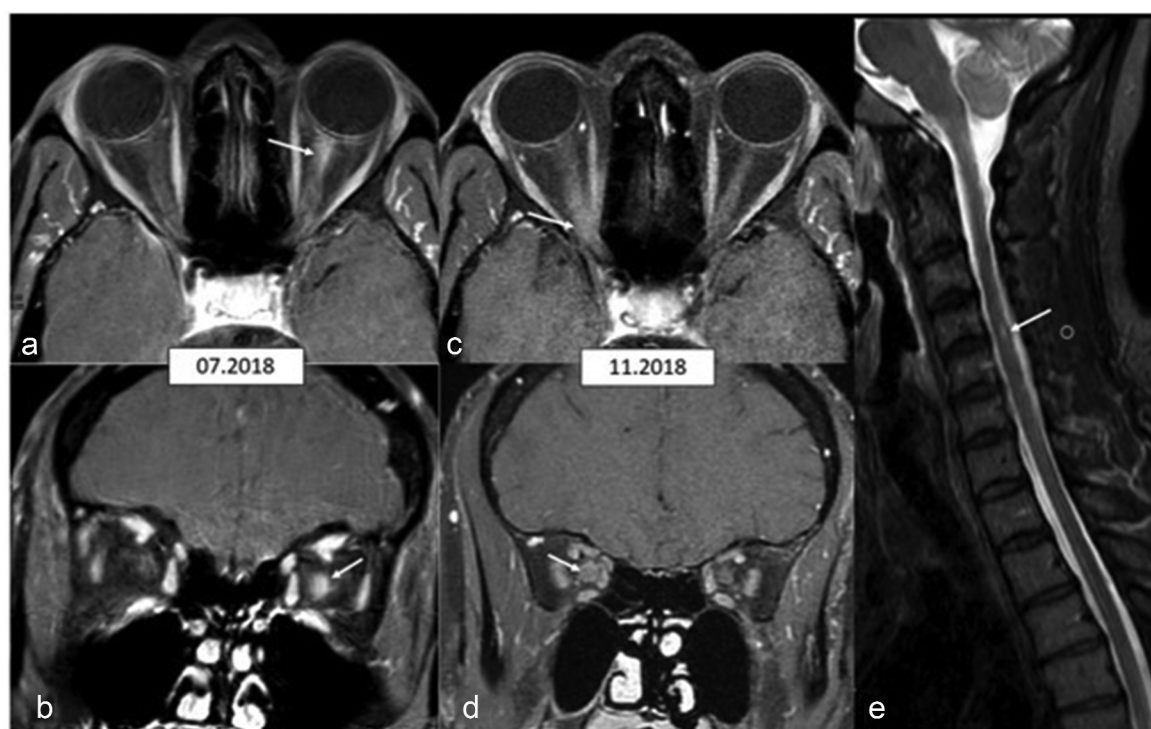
Magnetic resonance imaging. (a) Axial contrast-enhanced (CE) T1-weighted image with fat suppression (FS) at the initial presentation showing abnormal enhancement of the retrobulbar segment of the left optic nerve (arrowed). (b) Coronal CE T1-weighted image with FS at the same time as (a) confirming swelling and enhancement of the left optic nerve (arrowed). (c) Axial CE T1-weighted image with FS at the second presentation revealing swelling and abnormal enhancement of the intra-orbital segment of the right optic nerve (arrowed). (d) Coronal CE T1-weighted image with FS at the same time as (c) confirming swelling and enhancement of the right optic nerve (arrowed). (e) Sagittal T2-weighted image of the cervical spine revealing a non-specific small focus of abnormal signal intensity at the C4/5 level (arrowed).
